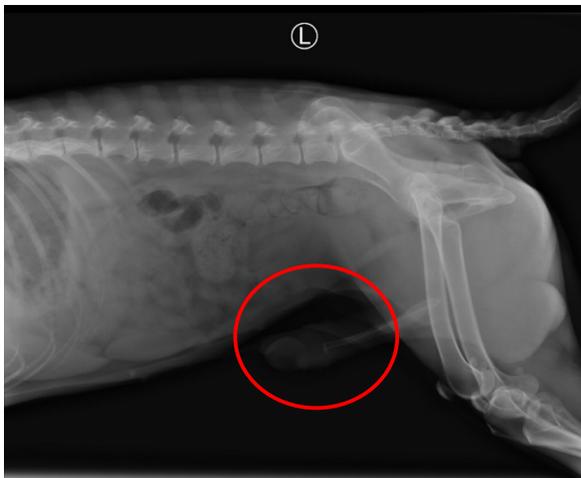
Lateral view of radiograph revealed the mass at the base of bulbus glandis (red circle) and there was no growth beyond that region.
